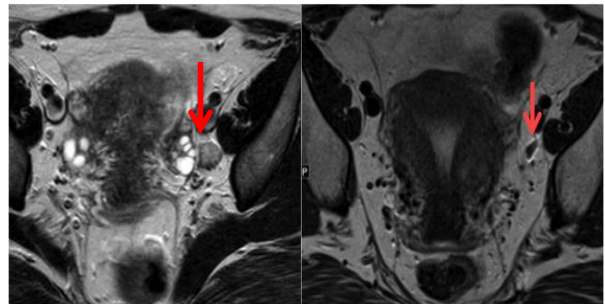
MRI showing presence of node before surgery (left) and absence after surgery (right).
